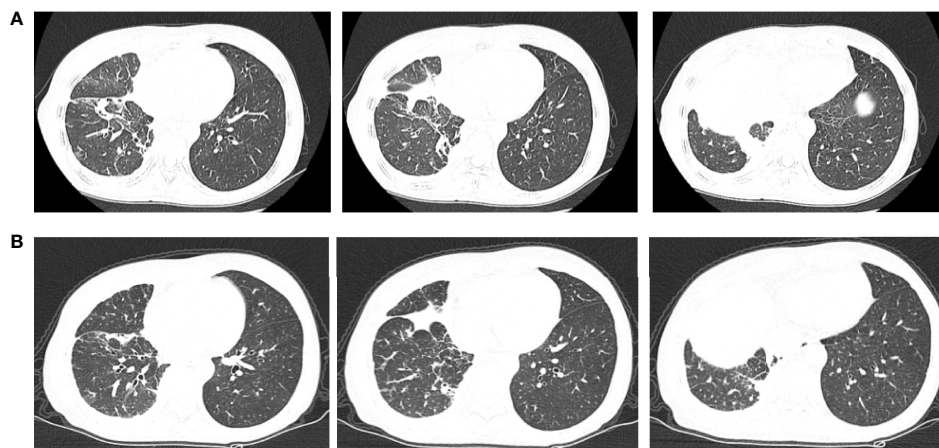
Chest computerized tomography (CT) scan images of patient two before and after one month of osimertinib treatment. (A) The images were before osimertinib treatment. (B) The images were receiving osimertinib treatment after one month.
